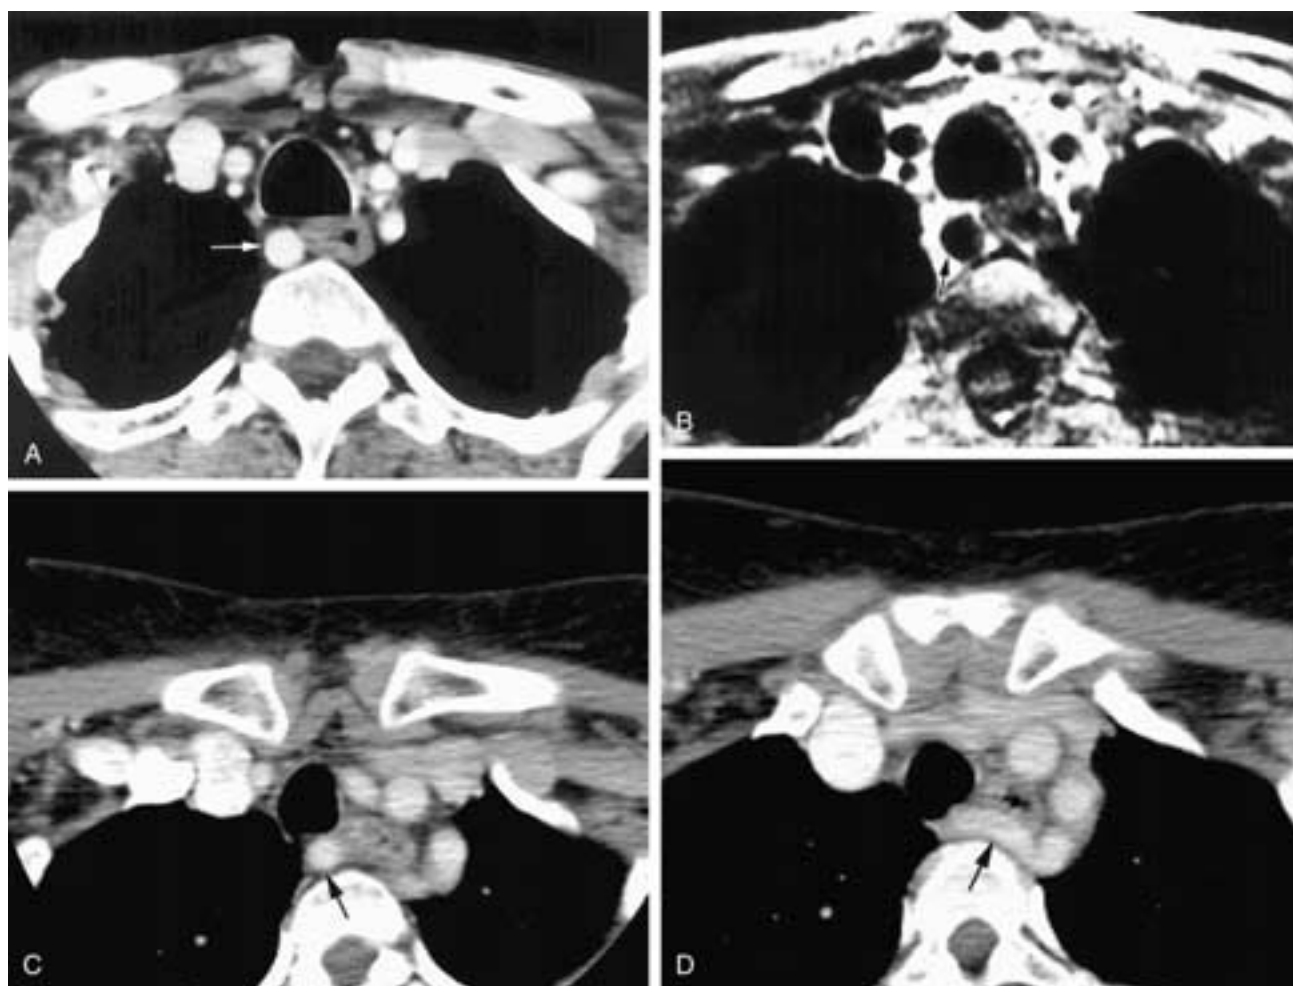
Axial contrast-enhanced CT scan (A) through the lower neck shows an aberrant right subclavian artery (arrow) adjacent to the cervical esophagus. A corresponding axial T1-weighted MR image (B) shows the aberrant artery (arrow). Cranial (C) and caudal (D) contrast-enhanced CT scans on another patient show an aberrant right subclavian artery (arrows) extending behind the cervical esophagus.
